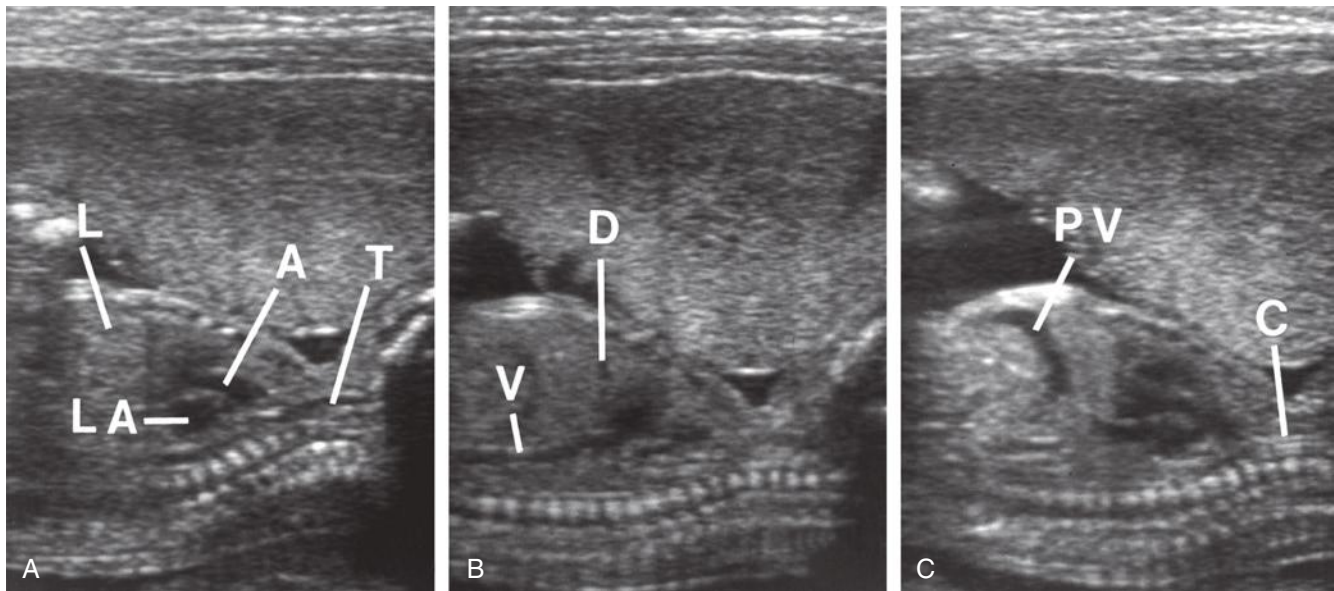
Relationships of mediastinal and neck structures. Midsagittal (A) and parasagittal (B and C) sonograms demonstrate the trachea (T) down to the level of the aortic arch (A). The cervical esophagus (C) lies posterior to the trachea in the neck (note again the muscular and mucosal layering). D, diaphragm; L, liver; LA, left atrium; PV, left portal vein; V, inferior vena cava.
